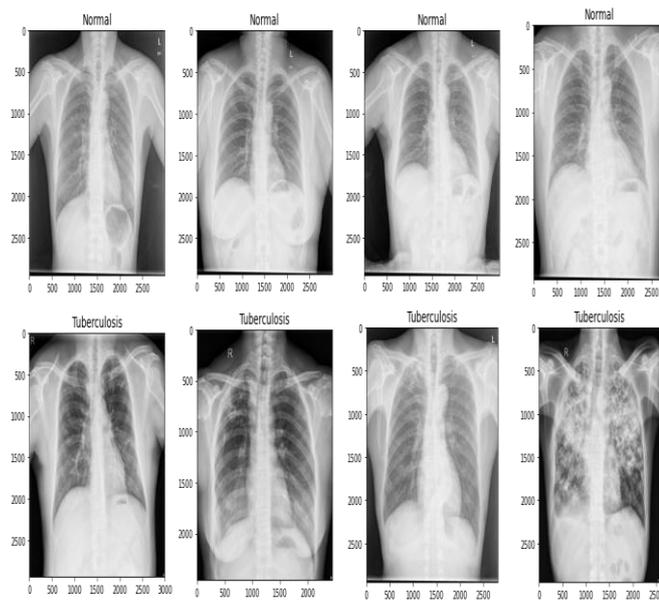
A glimpse of normal abnormal chest X-ray tuberculosis
